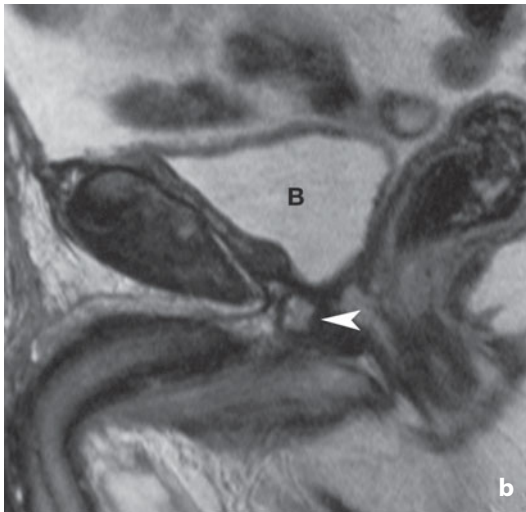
CT-PET with choline. Local recurrence after radical prostatectomy. a CT-PET shows a focus of radiotracer uptake at the vesicourethral anastomosis. b In the corresponding sagittal T2-weighted MR image the *arrowhead* indicates the nodule. *B*, urinary bladder
